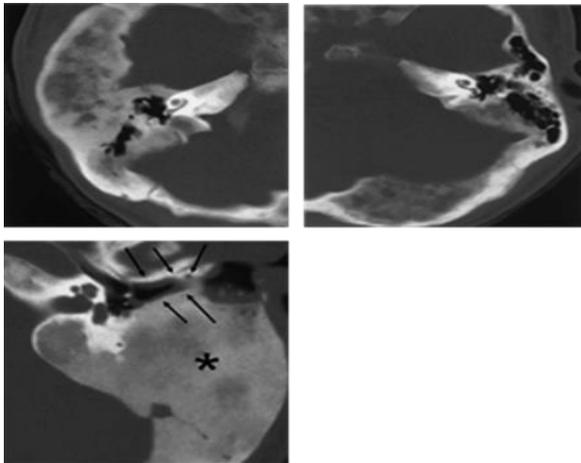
Fibrous dysplasia, pagetoid (a) axial cut CT scan right temporal, (b) axial CT scan left temporal, showed widespread heterogeneous thickening of the squamous and petrous temporal bone, (c) fibrous dysplasia, sclerotic. Extensive sclerotic appearance of the mastoid is characterized by increased bone volume (*). Changes in occlusion of external auditory canal were noted, often with arrow-pointed abnormalities
